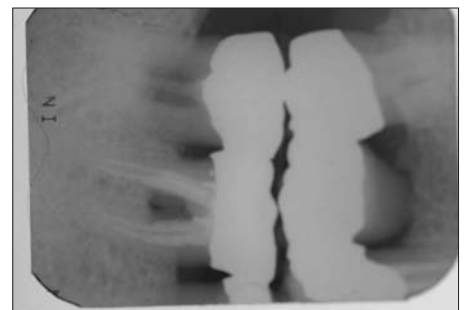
2002 bitewing radiograph with minimal changes compared to 1999. Patient has excellent oral hygiene since 1990 and has periodontal hygiene maintenance every three months.
